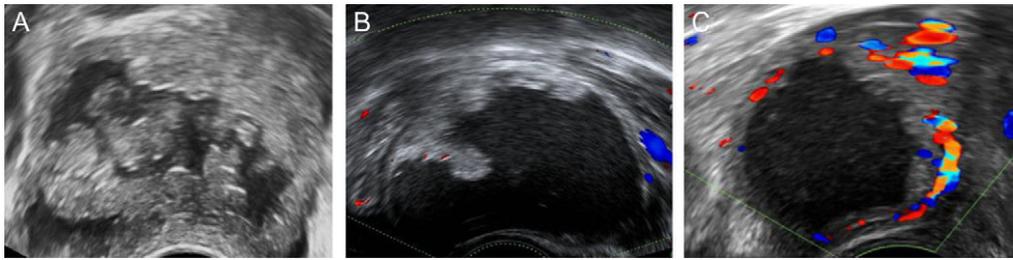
Sonographic appearances of decidualized endometrioma. Unilocular cysts containing hyperechoic fluid and an irregular internal wall with prominent echogenic rounded papillary projections (A). The papillary projections were typically highly vascular on Doppler examination (B and C). Reprinted with permissions from Pateman *et al.* (2014).
